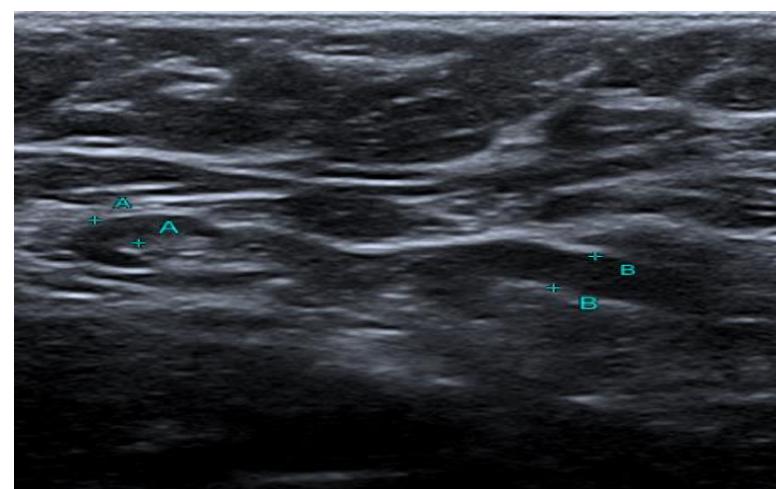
Ultrasound showing enlarged axillary lymph nodes
